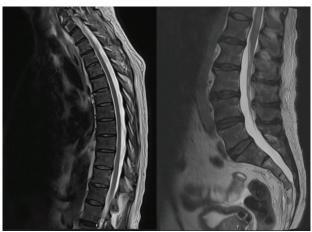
Neuroaxis MRI showing hypersignal in T2 in the posterior aspect of the spinal cord in the plane of D12 and superior plane of L1, suggesting partial involution of the findings compared to the MRI at admission.
